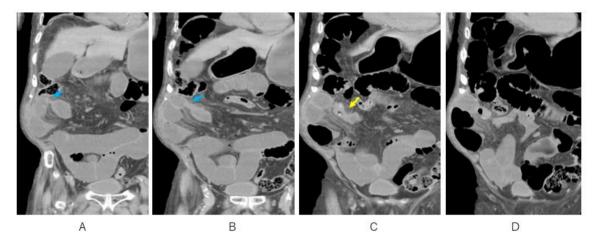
Two days later, occlusive site (A, B blue arrow) adjacent with swollen appendix (C, yellow arrow) are depicted on coronal CT. Note not only dilated bowel but constrictive bowel are depicted on D.
